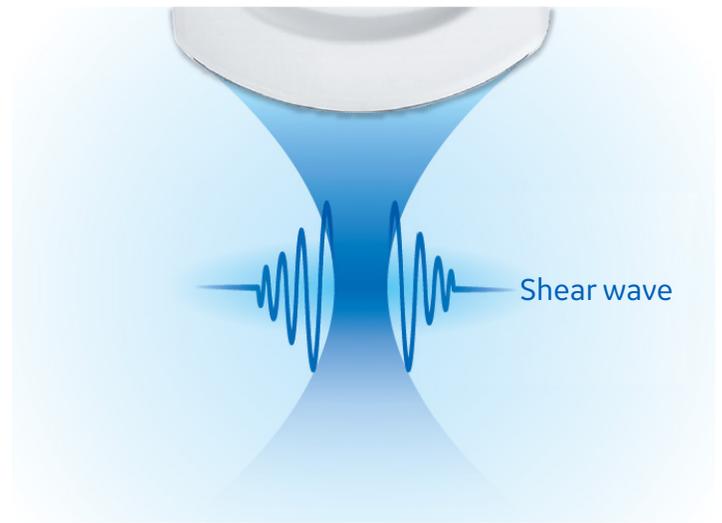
High intensity focused ultrasound beams can be used to push on tissue to generate shear waves, which propagate laterally away from the region of excitation.
